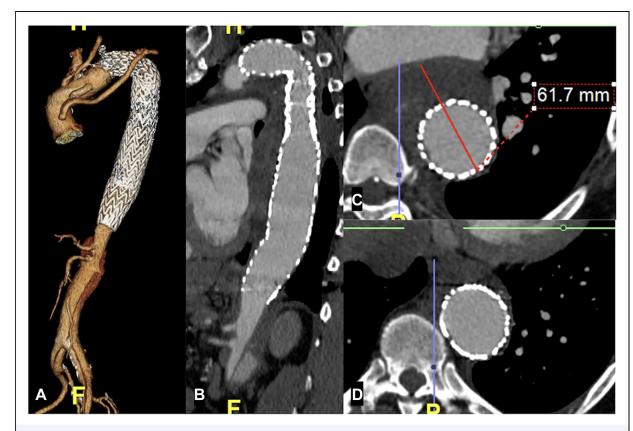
Postoperative contrast enhanced computed tomography imaging: (A) 3D aortic reconstruction, (B) Sagittal and (C, D) Coronal views of the aorta.
